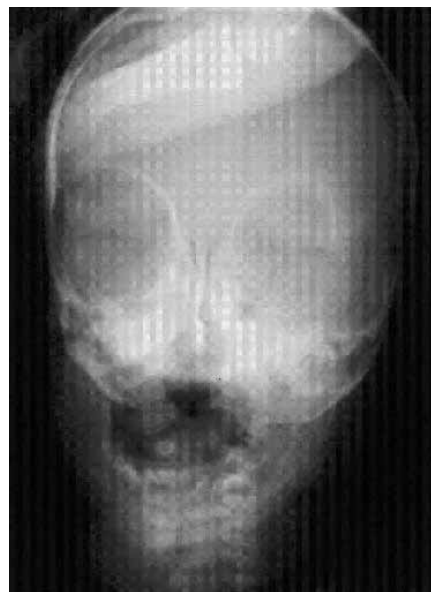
Atypical A-P x-ray of the skull: Diffuse massive cortical thickening of mandible with hyperostosis and bone enlargement. Other parts of the skull show normal radiological bone structure.
